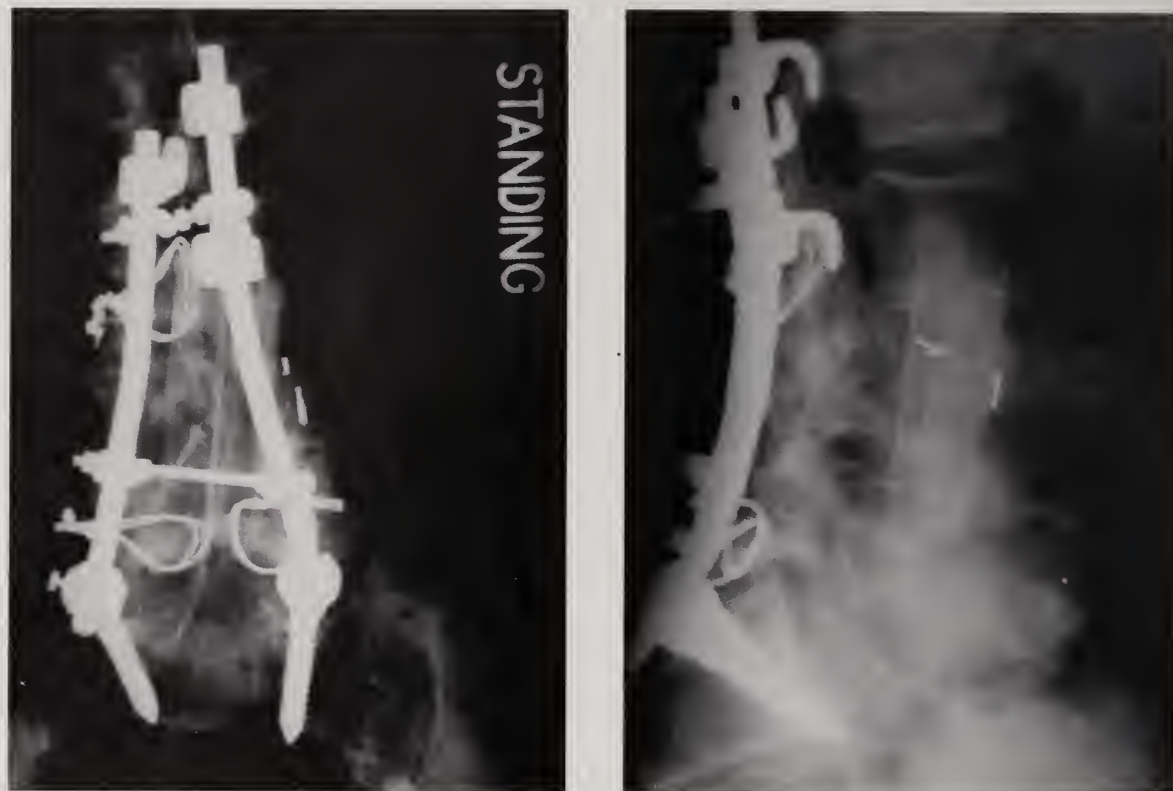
A and B. AP and lateral radiographs demonstrating final construct with posterior instrumentation stabilizing the anterior fibular strut graft.
